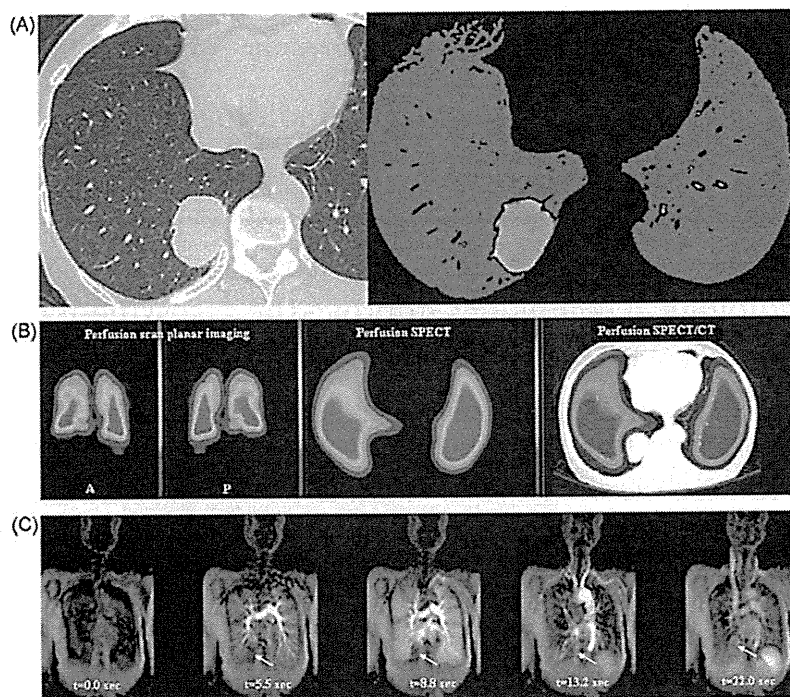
72-year-old female patient with squamous cell carcinoma in the right lower lobe. (A) L-R; thin-section CT and quantitatively assessed CT. Thin-section CT shows a mass in the right lower lobe, but no significant findings of emphysema. On quantitative CT, functional lung is shown in red, pulmonary emphysema in black, and lung cancer in white. There is slight emphysema in the right middle lobe and lingual segment. (B) L-R; anterior view of perfusion scintigraphy, posterior view of perfusion scintigraphy, SPECT and co-registered SPECT/CT. Perfusion scintigraphy shows reduced uptake of radioisotopes in the right lower lung field. Perfusion SPECT and co-registered SPECT/CT shows radioisotope deficiency due to lung cancer. In addition, the reduced uptakes in the middle lobe and lingual segment are thought to be due to emphysema. (C) L-R: $t=0$, 5.5, 8.8, 13.2 and 22.0 s. t indicates the time after bolus injection of contrast media. Dynamic perfusion MR images demonstrate heterogeneously enhanced lung parenchyma due to emphysema and a non-enhanced area due to lung cancer (arrow) for 5.5 and 8.8 s. Enhancement of the lung cancer became gradually stronger during 13.2 and 22.0 s.
